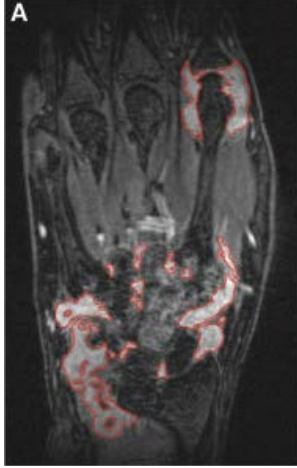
MRI of hand and wrist with marked region of interest.[5]
